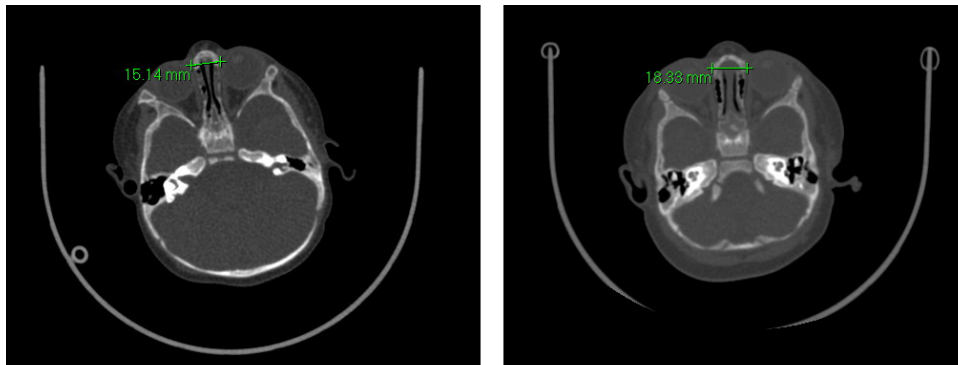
The bony interorbital distance calculated in an axial CT slice. Left: child with metopic synostosis. Right: control.
